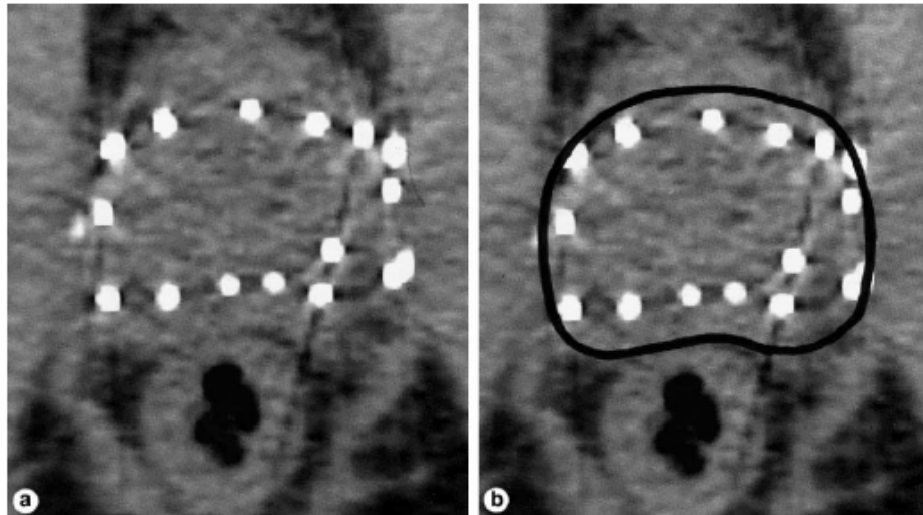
Transverse CT image of implanted prostate: (a) without contoured prostate; (b) with prostate contoured (Stock et al, 2002)
